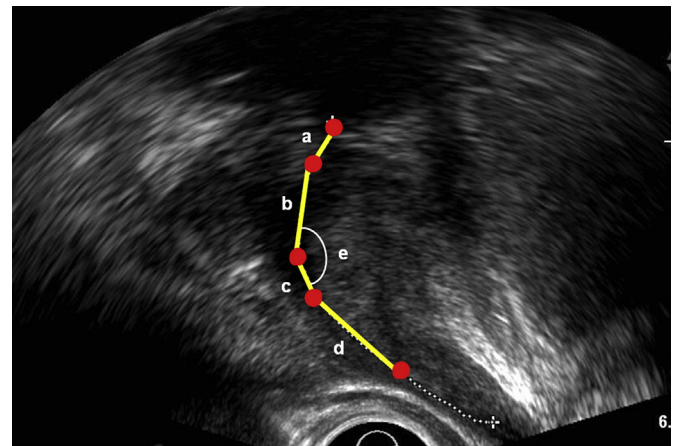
Ultrasonographic measurements of prostatic urethral length ($a + b + c + d$), transitional zone urethral length ($a + b + c$), and prostatic urethral angle (e) in a midsagittal image of a transrectal ultrasound.
